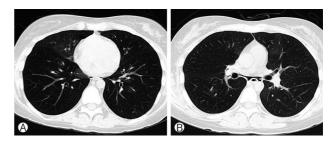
Chest CT upon diagnosis of BO. (A) Air trapping or persistent lucency of lung parenchyma during expiration of both lungs. (B) Bronchial wall thickening and bronchiectasis were apparent in all the visible lobes on chest CT. CT, computed tomography; BO, bronchiolitis obliterans.
